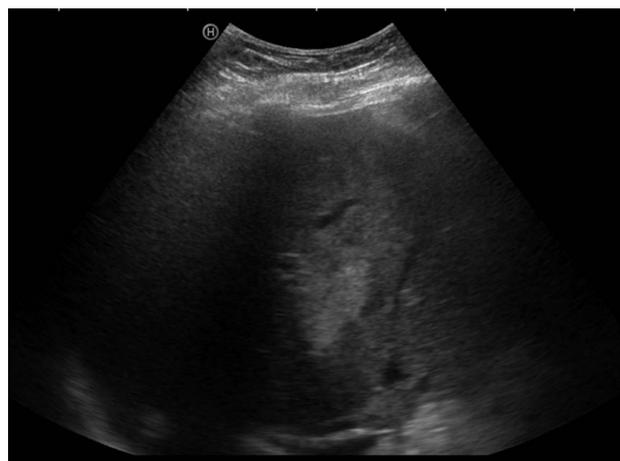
Ultrasound performed 18 months after liver transplantation showing an irregularly shaped hyperechogenic lesion of 5 cm in segment 8 in the transplanted liver.
